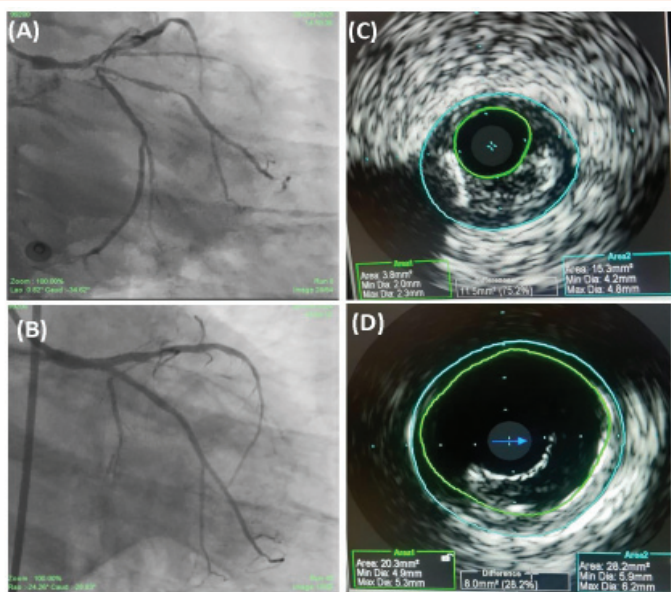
Case 1 - (A) and (B) Coronary Angiograms pre-and post-PCI; and (C) and (D) Intravascular ultrasound images pre- and post-PCI.
